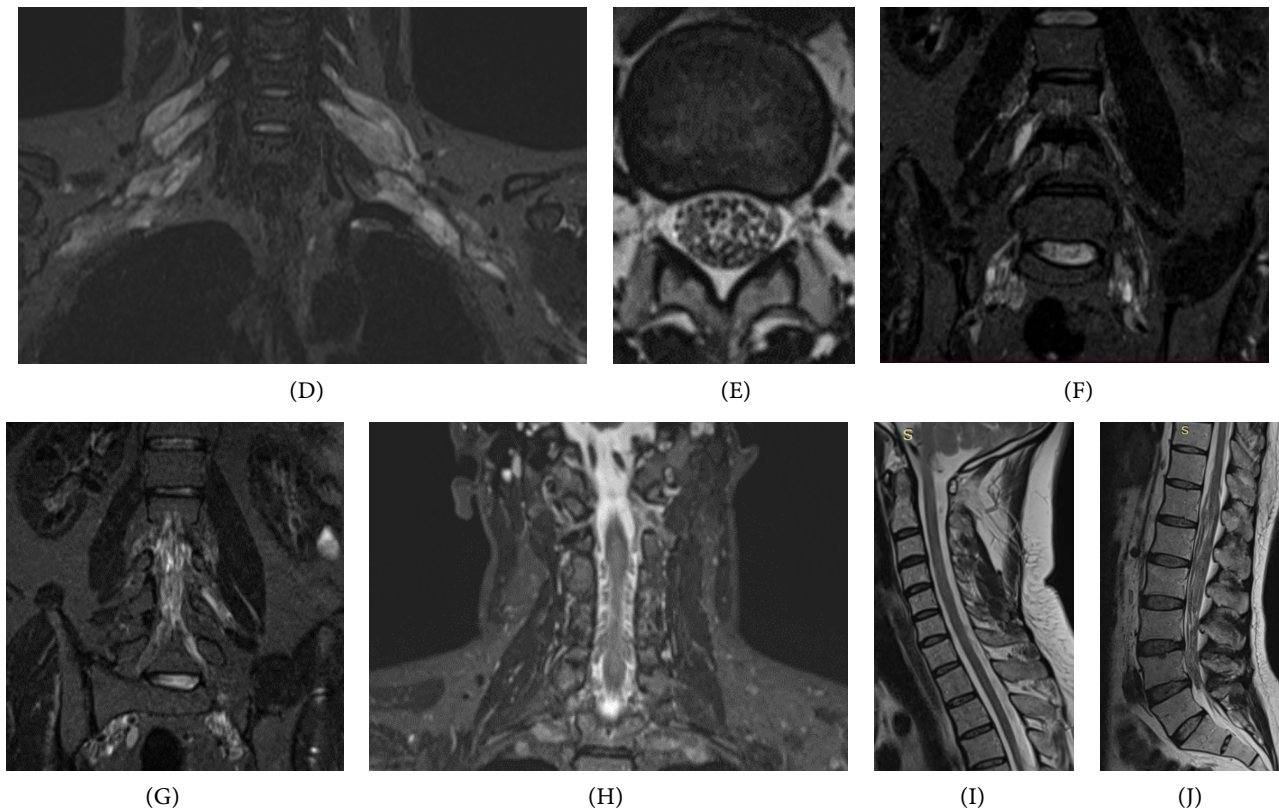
Brain MRI showing: (A), (B): Axial T2 and coronal FLAIR sequences revealing bilateral hyperintensities in the frontoparietal subcortical white matter; (C): Axial T1 with gadolinium contrast showing no contrast enhancement; (D): Coronal STIR sequence showing cervical root hypertrophy; (E): Axial STIR sequence showing root hypertrophy; (F), (G): Coronal sequences showing lumbar root hypertrophy; (H): Coronal STIR sequence showing cervical root hypertrophy; (I), (J): Sagittal T2-weighted sequences showing no compression in the cervical and lumbar spinal cord.
